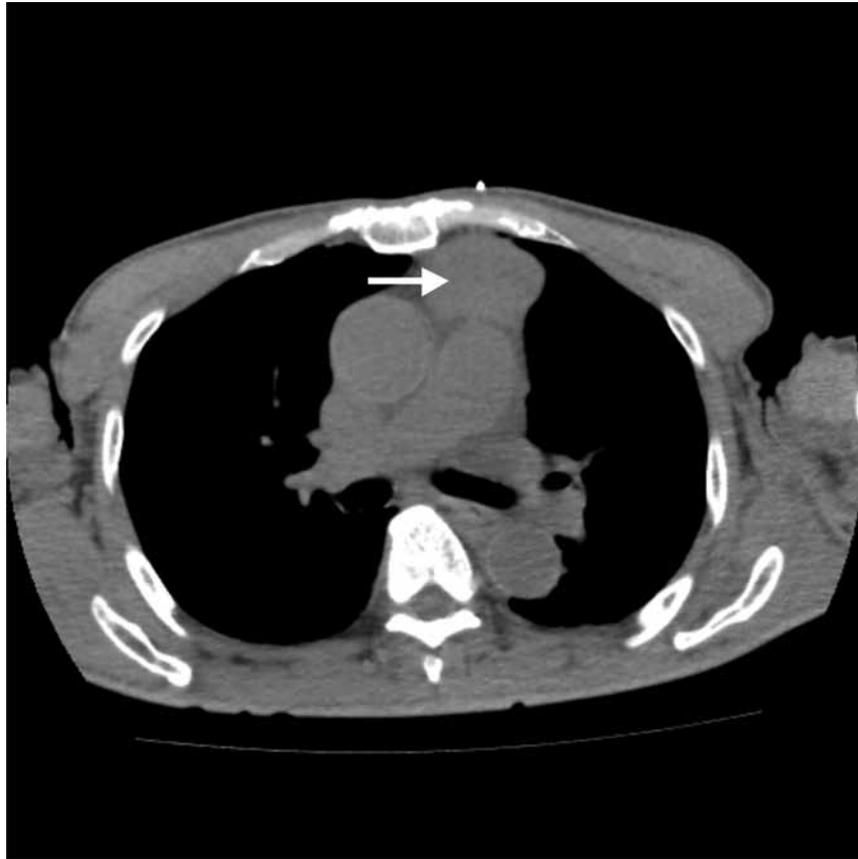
CT chest demonstrating the anterior mediastinal mass (arrow)
